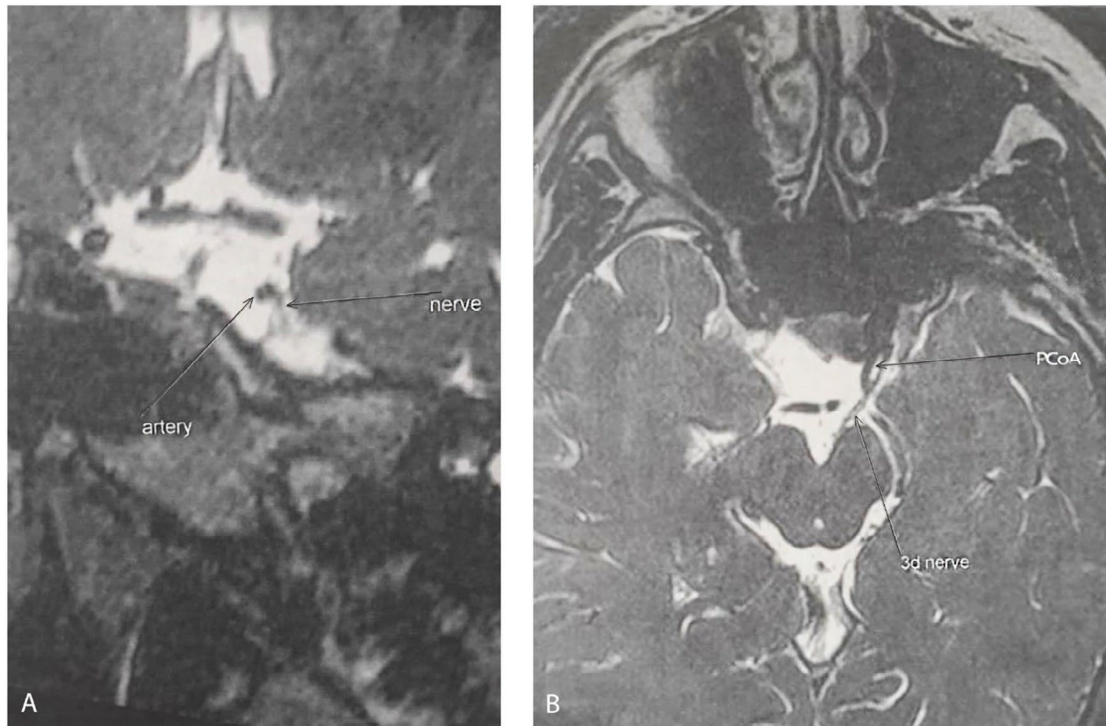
Oculomotor nerve compression. MRI image shows little aberration of PCoA inside the interpeduncular space (A), causing compression of the oculomotor nerve (B). 3d nerve, third cranial nerve; PCoA, posterior communicating artery
